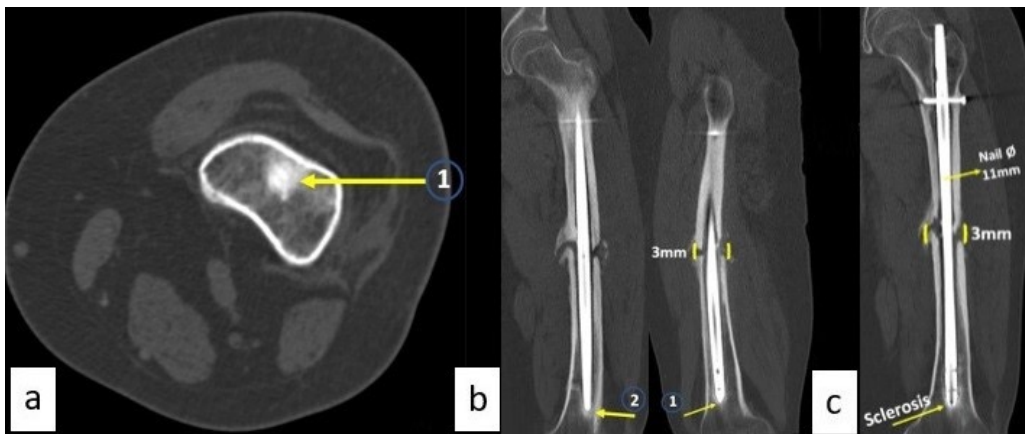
a,b-preoperative axial and sagittal views of nail tip corticalization; c- preoperative CT showing the gap and nail tip sclerosis; d-preoperative CT showing nail diameter, gap, and sclerosis.
